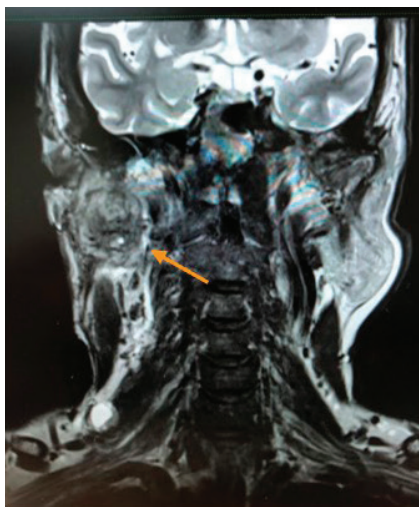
Coronal T2W1 MRI shows the right parotid mass (arrow) with sternocleidomastoid muscle involvement and multiple enlarged ipsilateral cervical lymph nodes.
